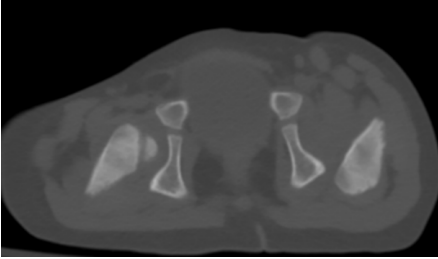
The normal control radiograph after reduction
